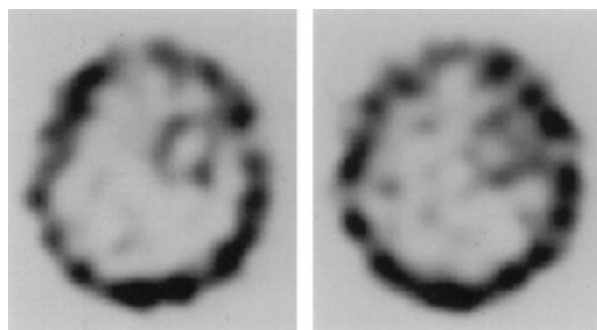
Tl-201 early (*left image*) and late (*right image*) brain SPECT in a 62-year-old man with brain abscess, 4.5 cm in diameter. The early uptake ratio (ER), the late uptake ratio (LR) and the ratio of LR to ER were 2.28, 1.56 and 0.68, respectively.
